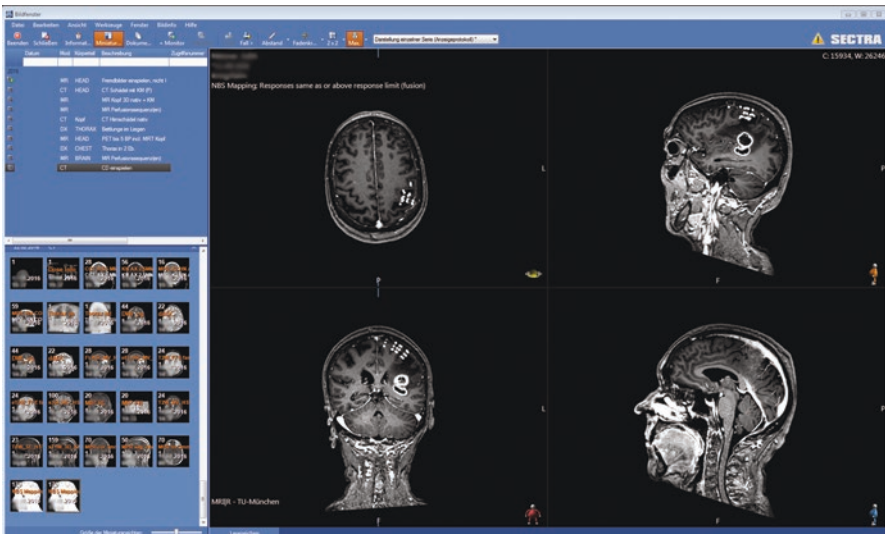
PACS data storage. The dataset containing the nTMS spots, projected on the original MRI sequence, can be stored in the PACS and accessed via the PACS viewer (here: IDS7, Sectra AB, Linköping, Sweden). Motor-positive nTMS spots are depicted in *white*
